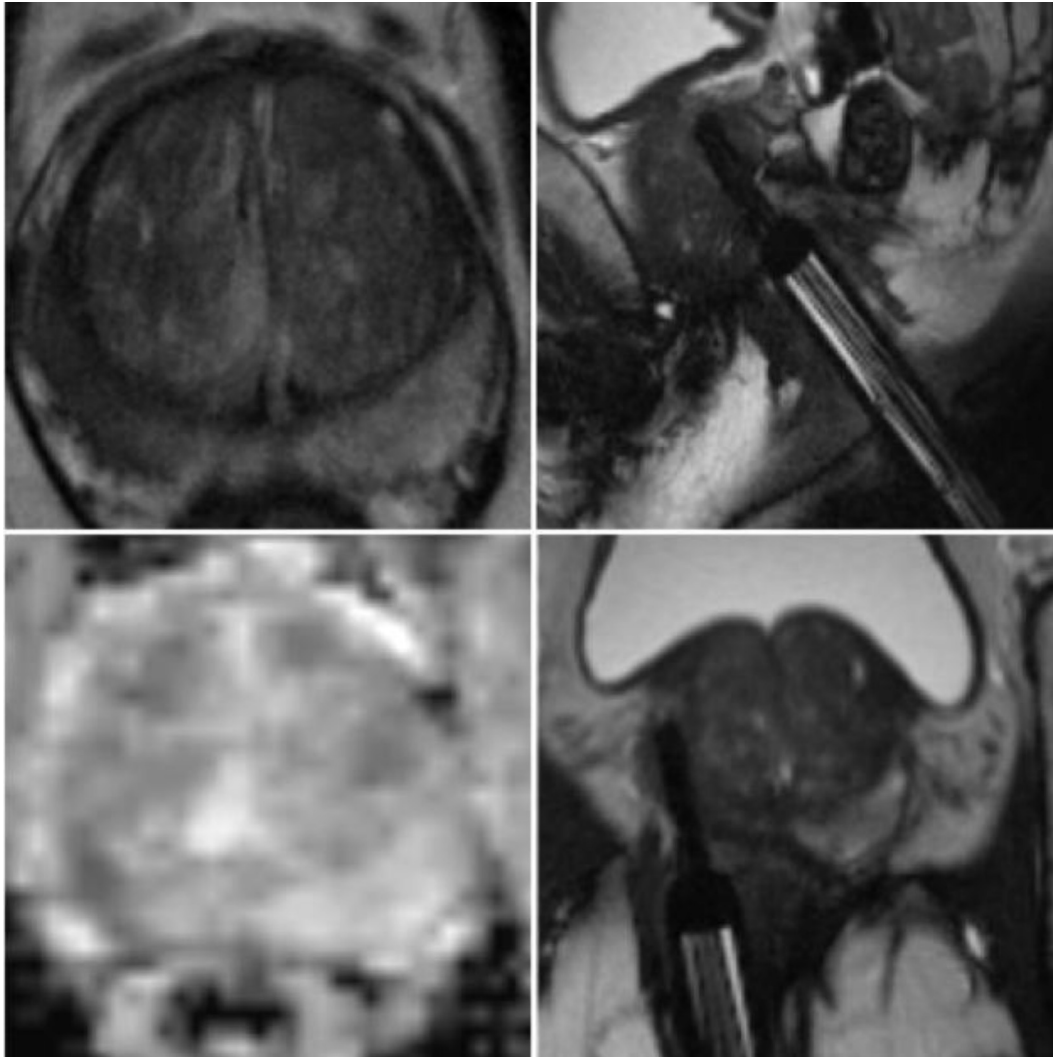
Case study showing: (Left) Preoperative mpMRI showing a PIRADS 5 (T2 and ADC sequences are displayed) right peripheral lesion in a men with a large prostate. FTB and random biopsy showed no cancer. (Right) subsequent IB one month later showed Gleason 3+4 =7. Confirmation of needle position in the sagittal and axial view is displayed. FTB = fusion-targeted biopsy; mpMRI = multiparametric magnetic resonance imaging.
